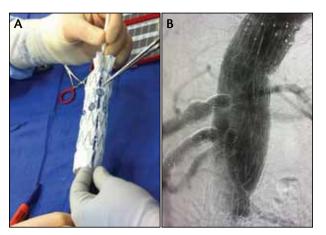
A 50-year-old MFS patient presented with a 7-cm aneurysm of the previous celiac-SMA-renal inclusion patch. Three-dimensional CT reconstruction was used to determine the fenestration locations (A) for subsequent stenting (B). The patient was discharged on postoperative day 2.
